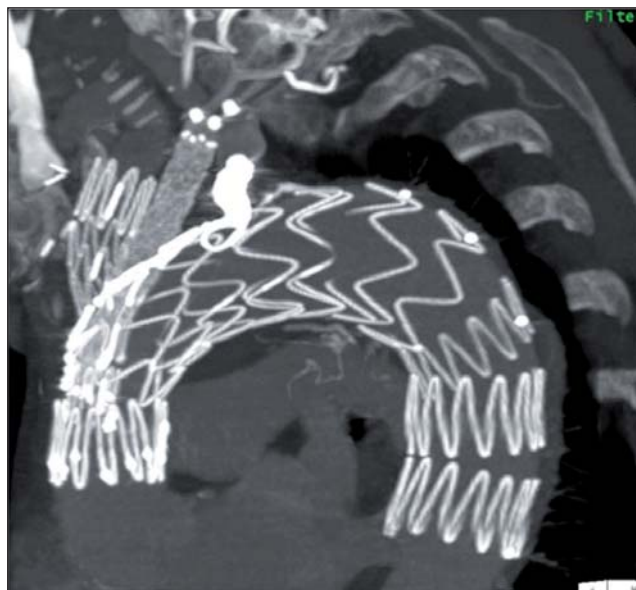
Completion CT scan after total endovascular arch repair using a branched prosthesis. Courtesy of Dr. Timothy Resch, University Hospital Malmö, Sweden.
